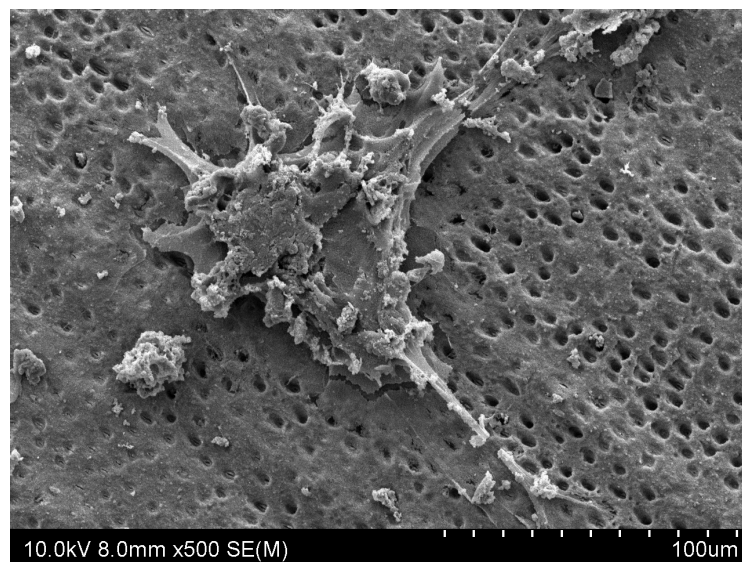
Larger osteoclast observed under SEM. Some osteoclasts that were not completely removed by ultrasonic bath can still be seen on the dentin surface.
